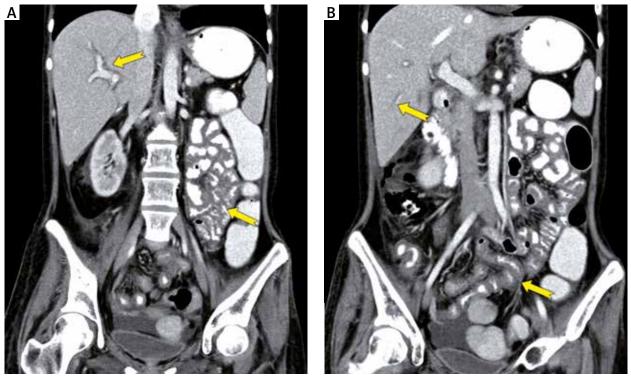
A–B) A 16-year-old girl with acute lymphoblastic leukaemia. Coronal CT images performed 38 days after haematopoietic stem-cell transplantation reveal periportal oedema (upper arrows) and moderate wall thickening of the small bowel (lower arrows). The patient died of GVHD
